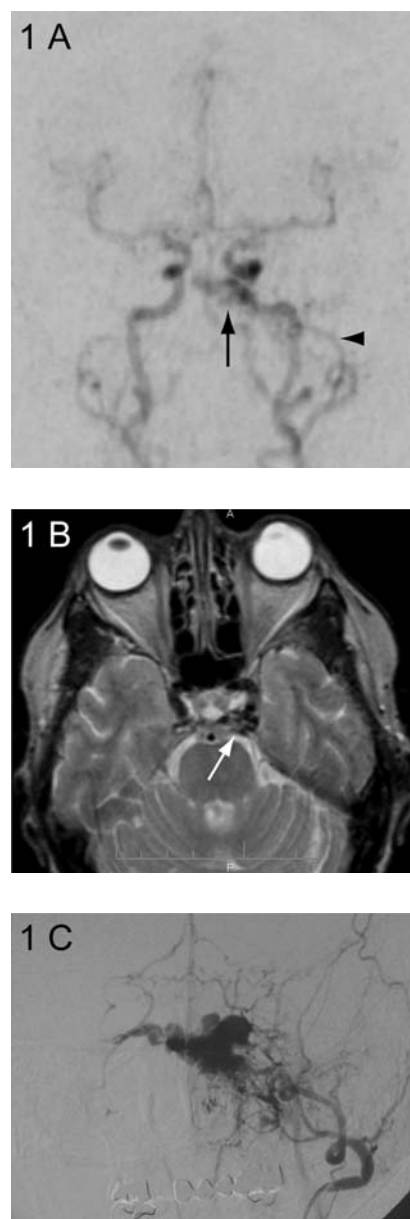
A: MR DSA image during the early arterial phase. Note the early flow into the cavernous sinus (arrow) from a prominent artery (arrowhead) on the left side. From the anatomical course the feeding vessel is probably the maxillary artery. However, because there is only one image plane (frontal view), leading to limited spatial resolution compared to conventional DSA, a detailed characterisation of the feeding vessels is not possible. B: T2-weighted image at the level of the cavernous sinus. Note the signal loss located medially to the internal carotid artery (arrow), representing flow-voids caused by fast flowing vessels of the fistula. C: Conventional DSA image (obtained in the arterial phase with the catheter positioned in the left maxillary artery) depicts multiple feeders of the CCF
